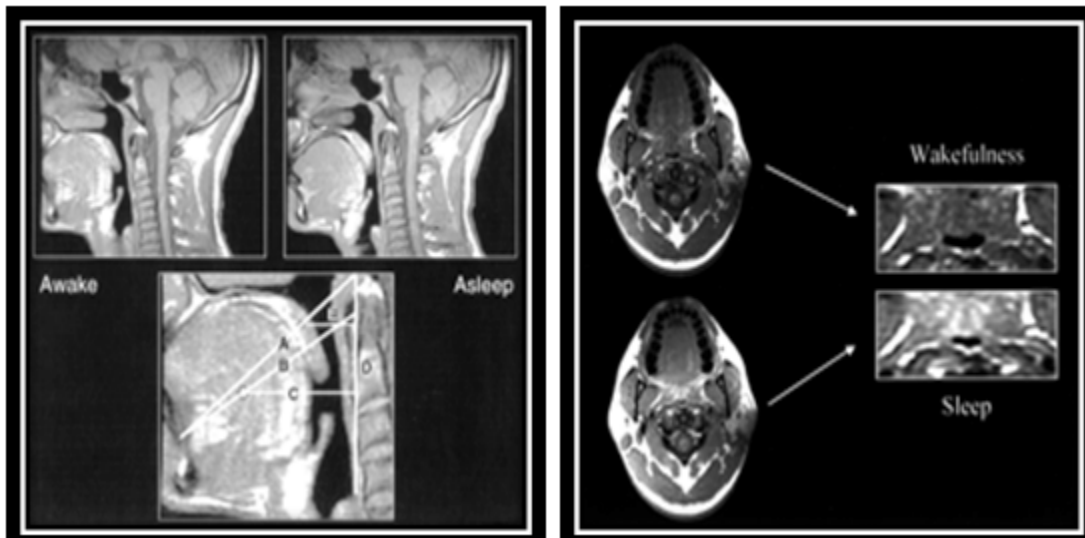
MRI Using Mullers Manoeuvre.
